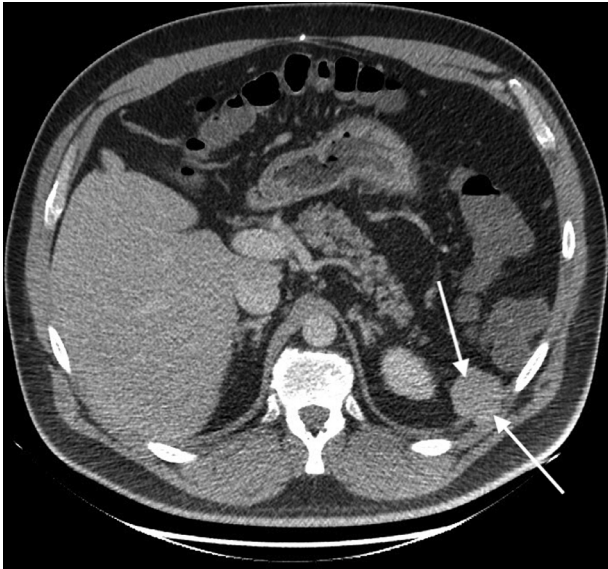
CT enhanced image, axial projection, displaying splenosis (arrows) traversing a diaphragmatic defect.
